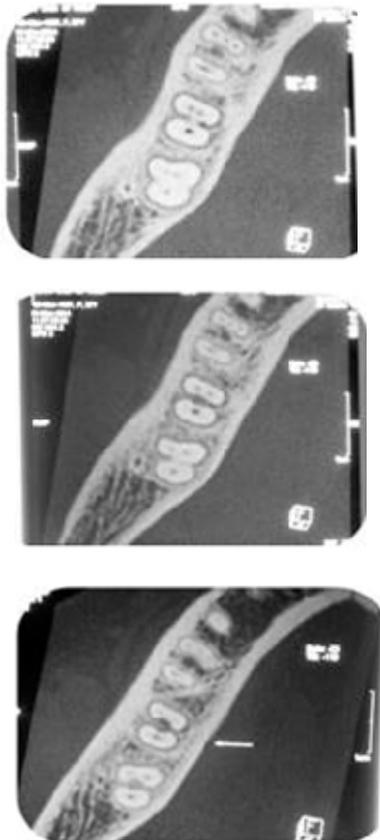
a. Coronal CBCT slice of right mandibular first molar at various levels
